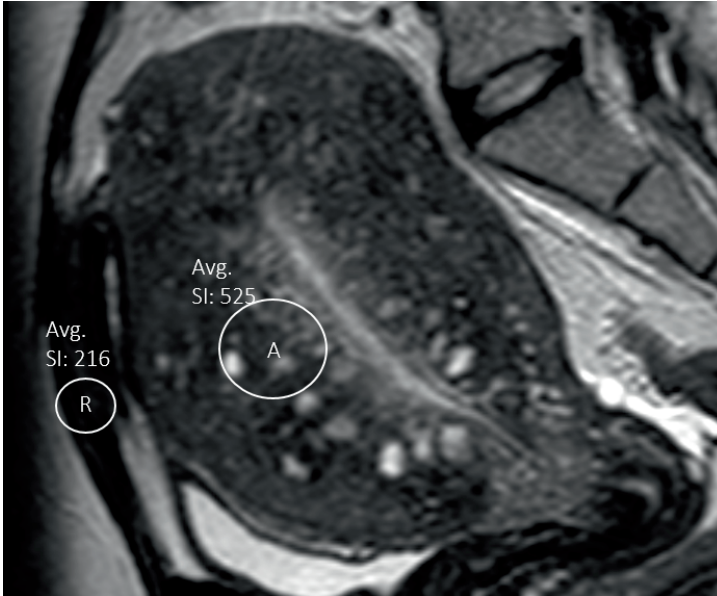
Sagittal T2W MRI showing an example of adenomyosis tissue (A) signal intensity (SI) versus that of the rectus muscle (R)
